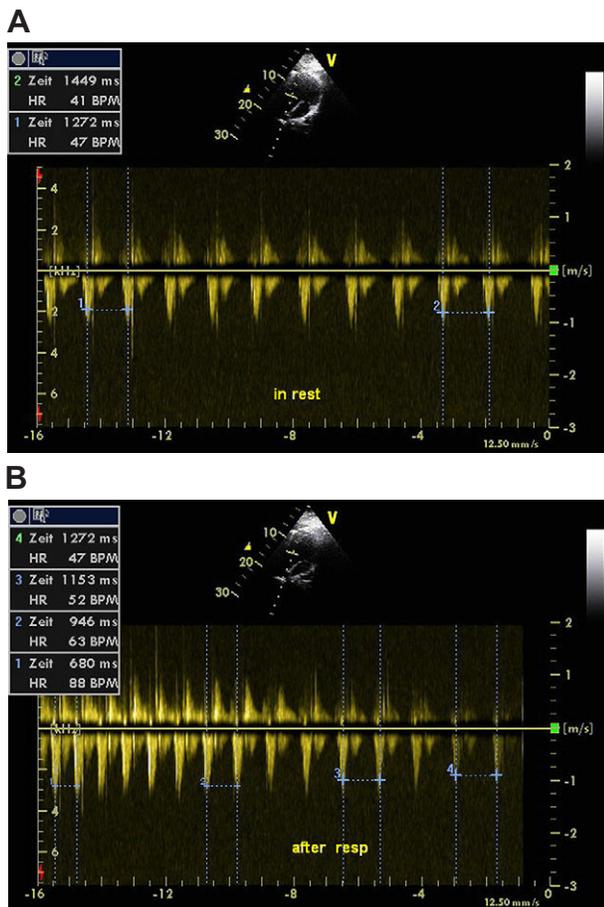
Transthoracic ultrasound data during rest. Data showing f_H and aortic flow during rest for a period (A) in between breaths or (B) immediately following a breath.
